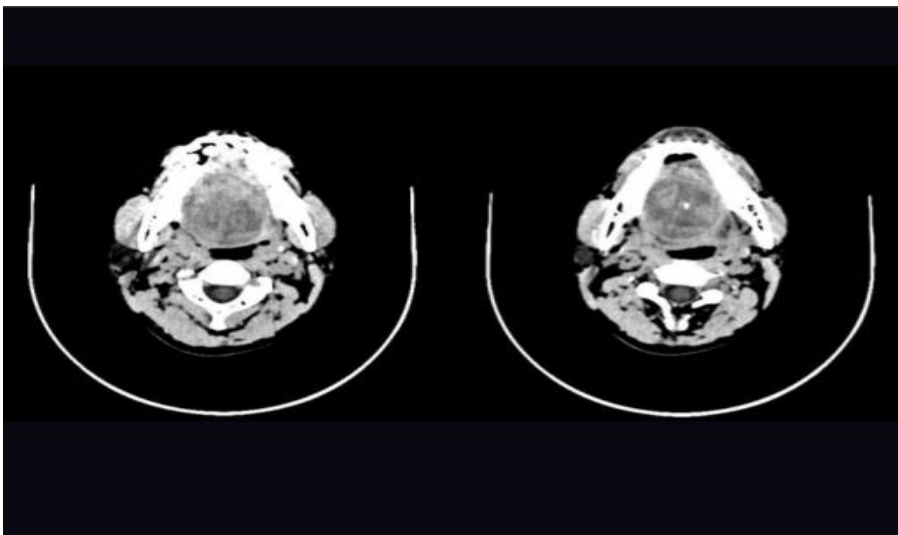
5. On CT scan, the lesion appears as a well circumscribed, heterogenous soft tissue density mass with 2-3 small foci of calcification within it. The soft palate is uninvolved however mild mass effect and posterior displacement compromising oropharyngeal air way.
